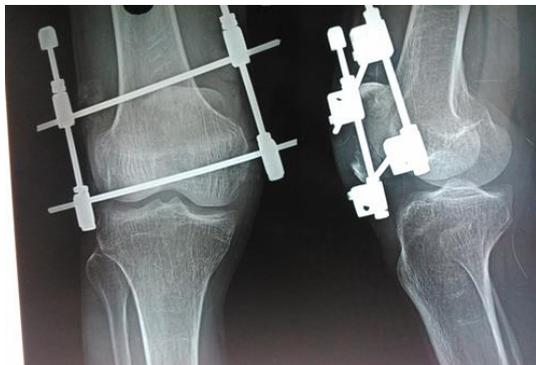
X-ray showing external assembly with k-wire and compression assembly.
